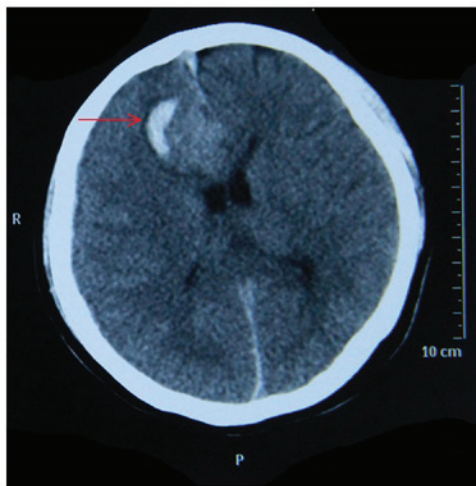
Preoperative computed tomography scan showed an intracranial hematoma in the right frontal lobe (red arrow) and a subarachnoid hemorrhage.
